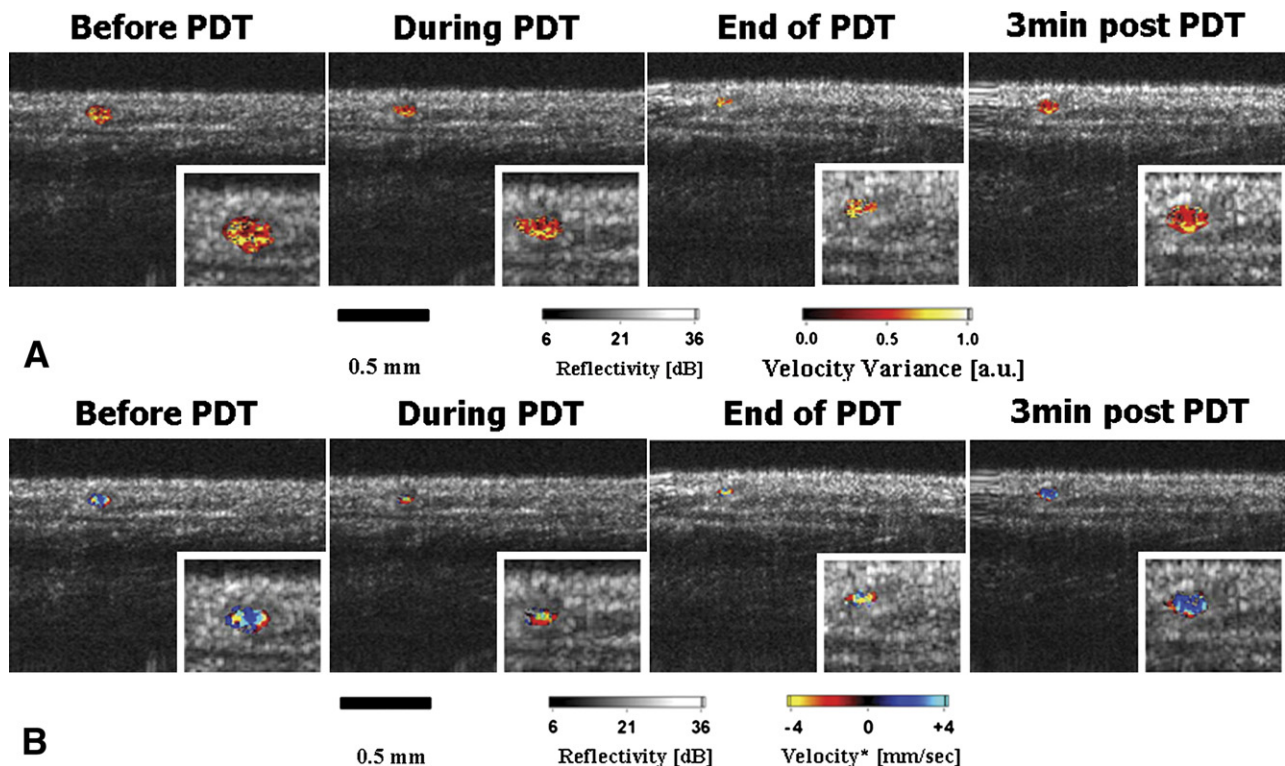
DOCT monitoring of the esophagus before (0-2 minutes), during (2-27 minutes), and after (27-30 minutes) PDT light exposure, for a total imaging time of 30 minutes. *Inset boxes* represent $\times 1.5$ magnification of the detected blood vessel. A, Blood flow is color coded by the detected velocity variance images; a noticeable reduction in the vascular index was seen during treatment, with recovery in the posttreatment period. B, Color-Doppler images of corresponding vessel.
